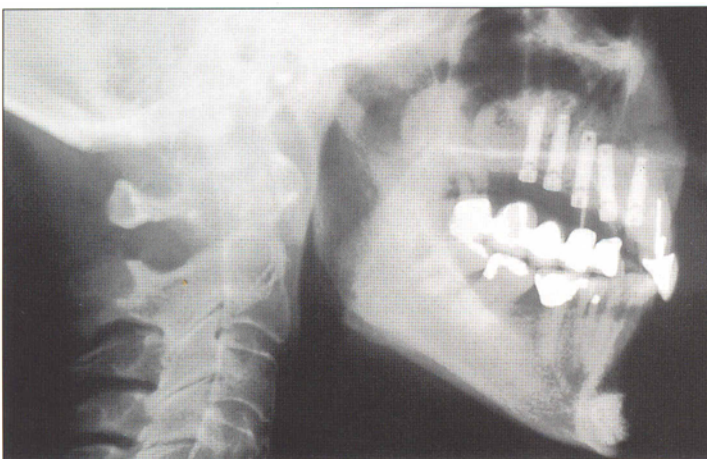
The lateral cephalometric radiograph reveals the implants placed in the grafted maxilla and the mandibular symphysis donor site grafted with resorbable hydroxyapatite.
